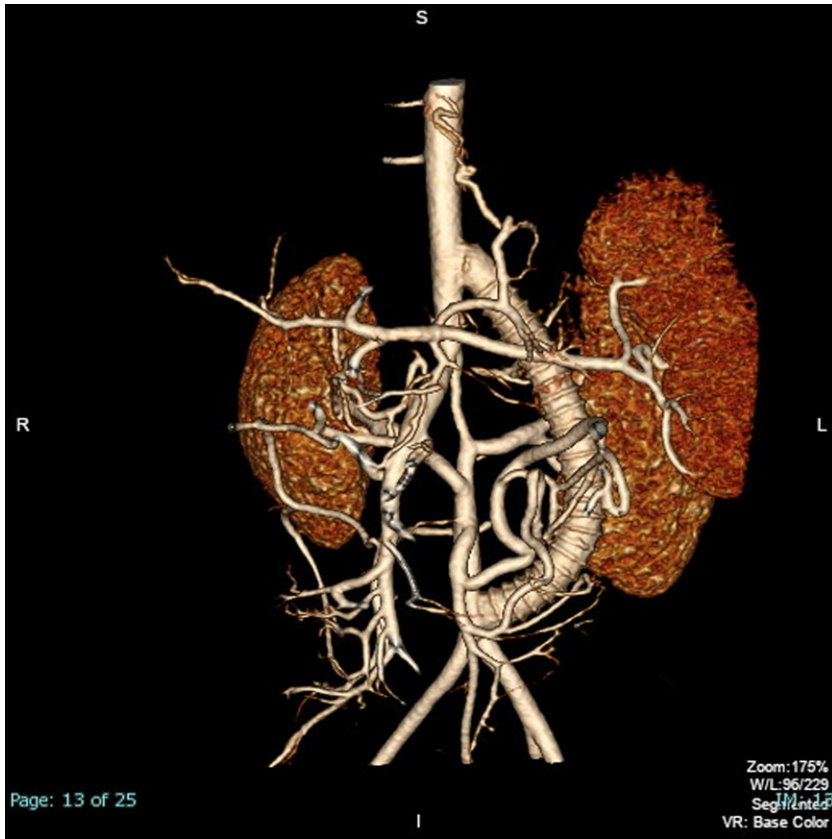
3-dimensional reconstruction of computed tomography angiography after repair demonstrating a polytetrafluoroethylene graft around the stenotic region and normal caliber renal arteries.
